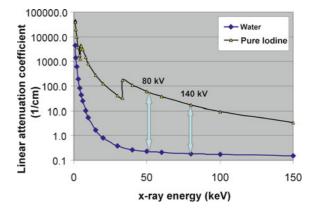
Linear attenuation coefficients of iodine and water as a function of X-ray energy. The *arrows* indicate the difference of linear attenuation coefficients between iodine and water at the mean energy of a typical 80 kV and 140 kV X-ray beam. Data are from National Institute of Standards and Technology (NIST) website: http://www.nist.gov/physlab/data/xraycoef/index.cfm
